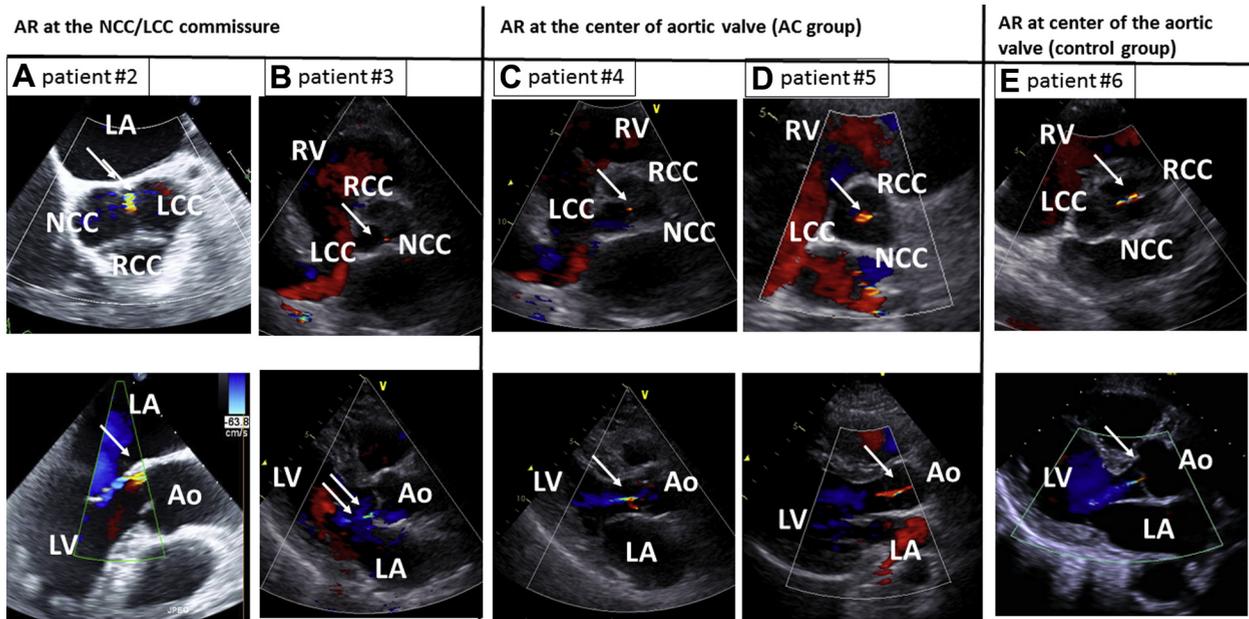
Echocardiography of iatrogenic AR in patients 2–6. A: Patient 2: AR at the NCC-LCC commissure observed on transesophageal echocardiography 1 day after the ablation procedure (arrow). B: Patient 3: AR at the NCC-LCC commissure observed on transthoracic echocardiography 1 day after the ablation procedure (arrow). C–E: Patient 4 (panel C), patient 5 (panel D), patient 6 (panel E): AR at the center of the aortic leaflets observed on transthoracic echocardiography 1 day after the ablation procedure (arrow). Ao = aorta; AR = aortic regurgitation; LA = left atrium; LCC = left coronary cusp; LV = left ventricle; NCC = noncoronary cusp; RCC = right coronary cusp; RV = right ventricle.
